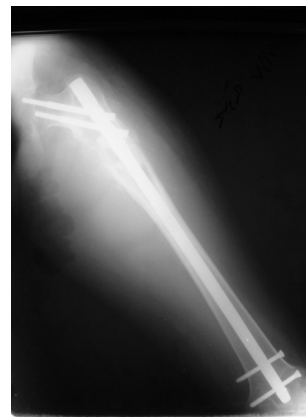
Anteroposterior radiograph of the entire femur 6 months after curettage and cephalo- medullary nail fixation showed a lytic lesion and soft tissue swelling in the sub trochanteric area
